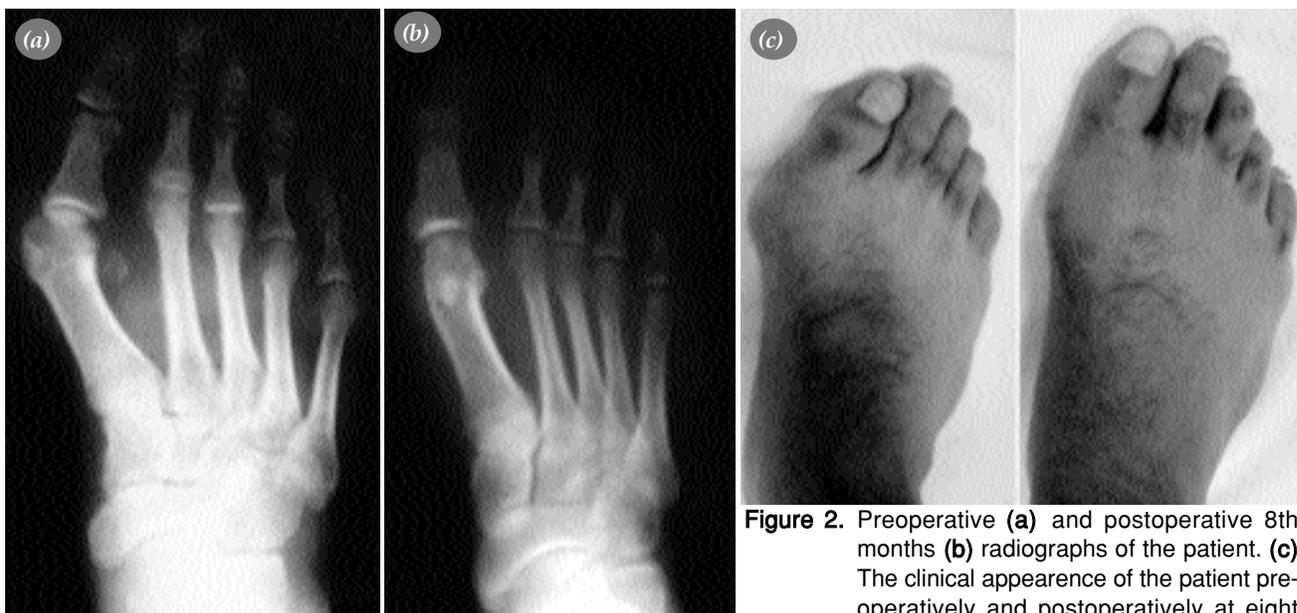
Preoperative (a) and postoperative 8th months (b) radiographs of the patient. (c) The clinical appearance of the patient preoperatively and postoperatively at eight months.
